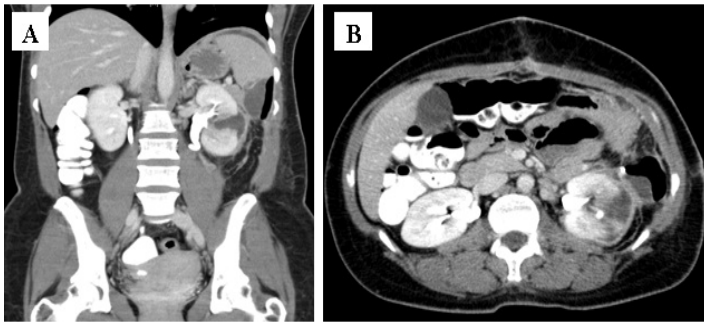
Repeat CT on hospital day 14. A) Coronal view, B) Axial view.
